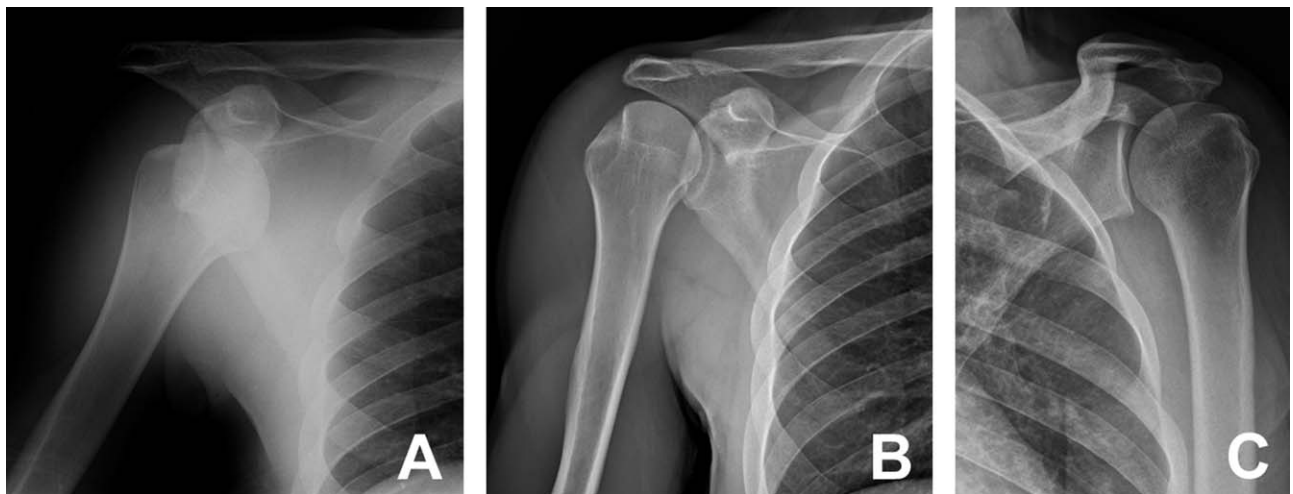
X-ray taken from a recruited patient with shoulder lower anterior dislocation (A) and after reduction with external technique (B); control subject (C).
